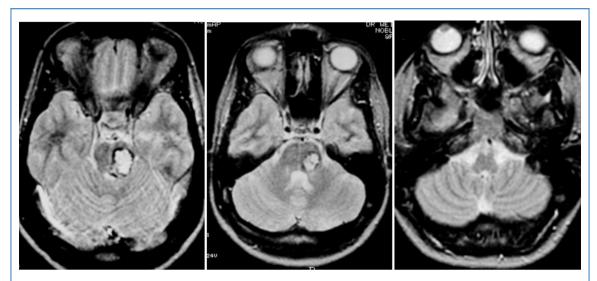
Magnetic resonance imaging scan at presentation. The patient was experiencing only diplopia, mild unsteadiness, and mild hearing loss in 1 ear.
